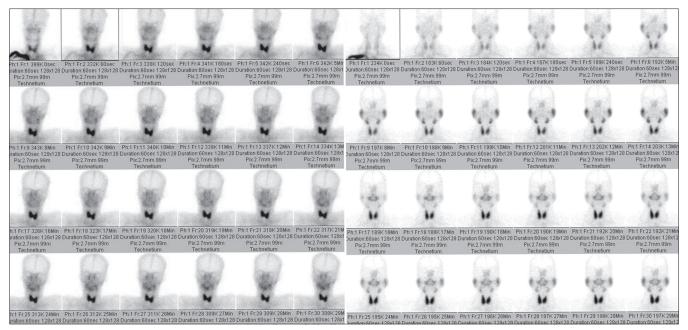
Salivary scintigraphy showing markedly diminished salivary gland flow, including delayed uptake, reduced concentration, or delayed secretion of the tracer (left) when compared to normal (right)
